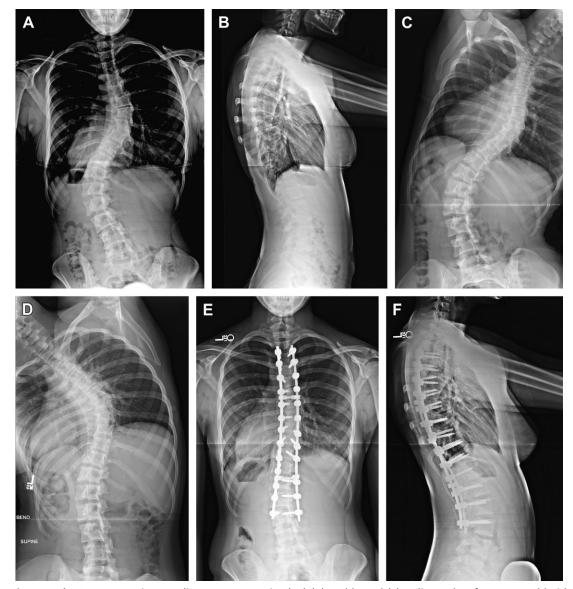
Lenke 6. Preoperative standing posteroanterior (PA) (A) and lateral (B) radiographs of a 14-year-old girl with a left 52° main thoracolumbar curve and a right 42° thoracic curve. Right (C) and left (D) bend films show that the main thoracolumbar curve bends down to 27° and the thoracic curve bends down to 29°. One-month follow-up PA (E) and lateral (F) radiographs show correction of the main thoracolumbar curve to 19° and correction of the thoracic curve to 17° with posterior pedicle screws from T2-L3.
